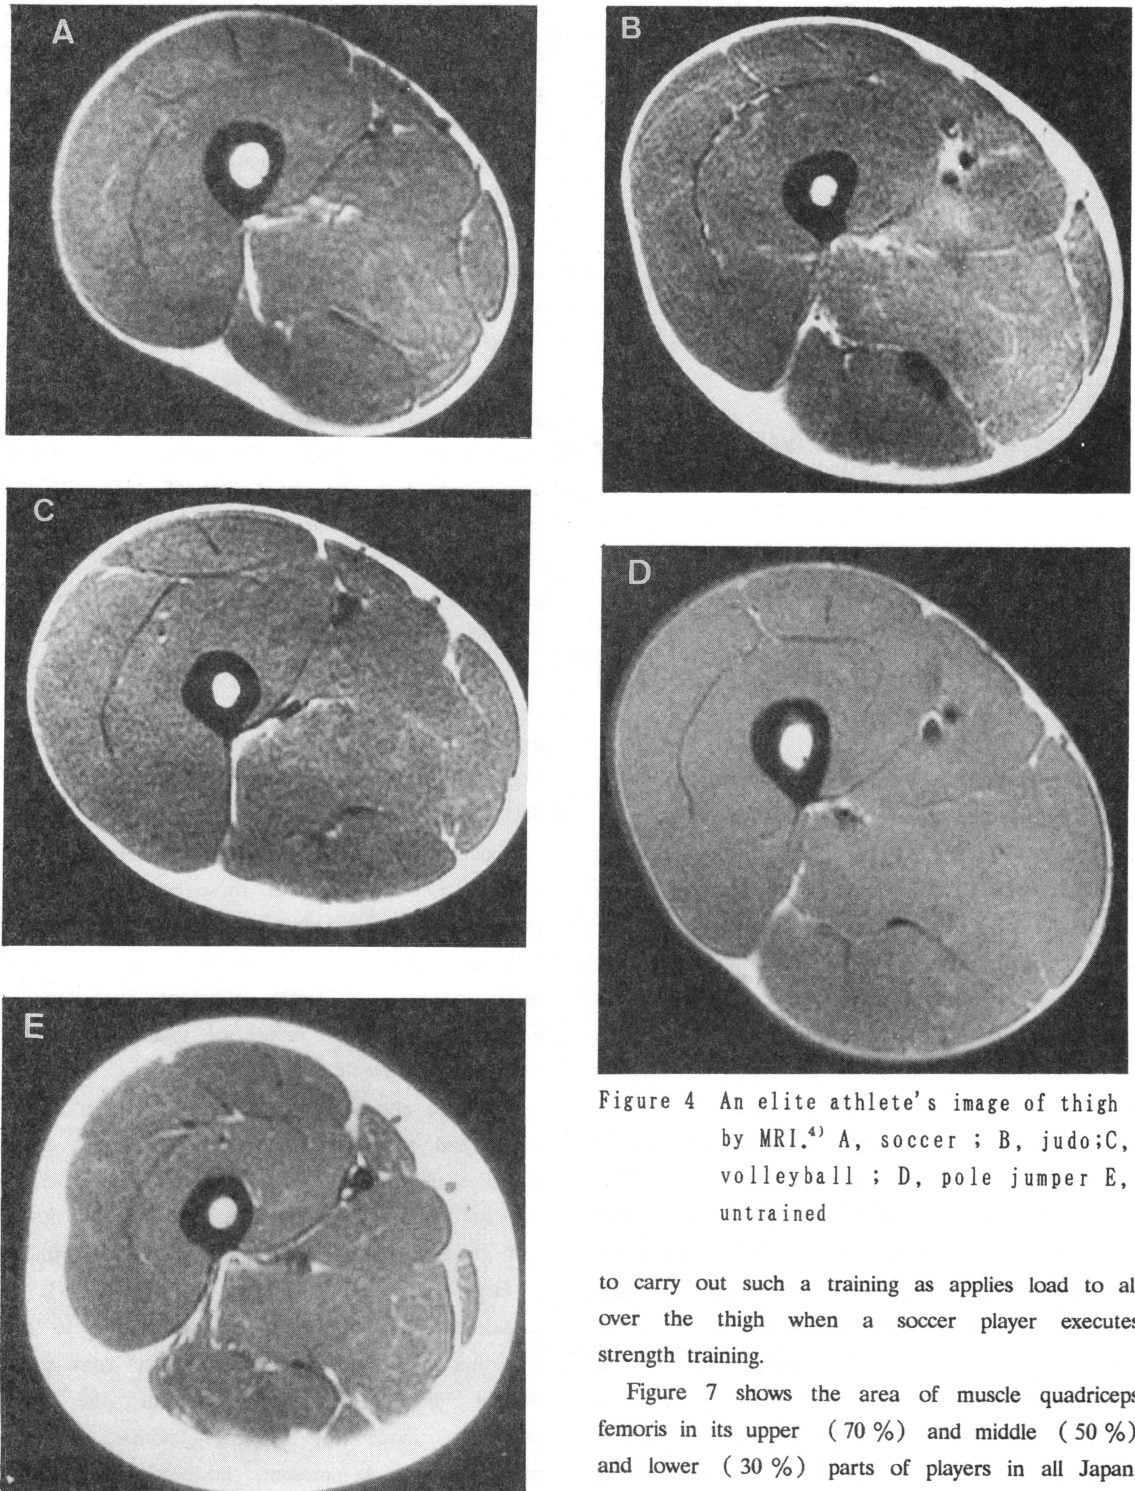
An elite athlete's image of thigh by MRI.⁴⁾ A, soccer ; B, judo; C, volleyball ; D, pole jumper E, untrained
